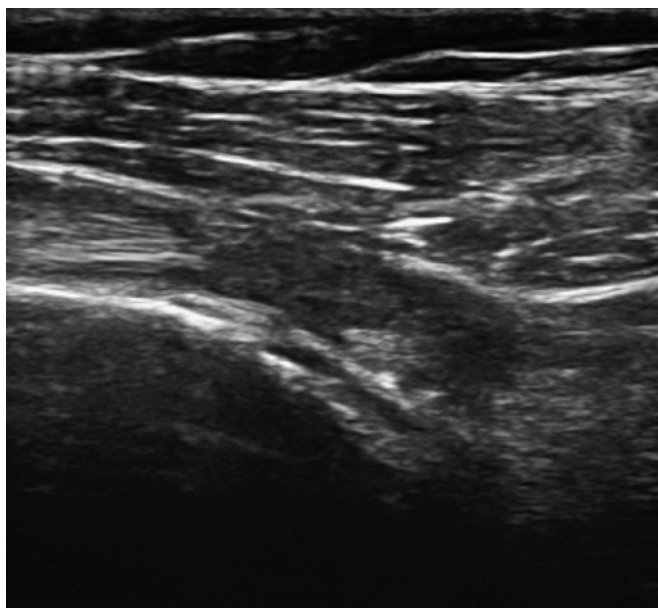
In the same patient as in Figure 20-17, the scan shows more distally a hypoechoic zone where it appears that the normal fibrillar pattern is disconnected, giving the impression of a biceps tendon tear. The tear could not be confirmed on MRI.
